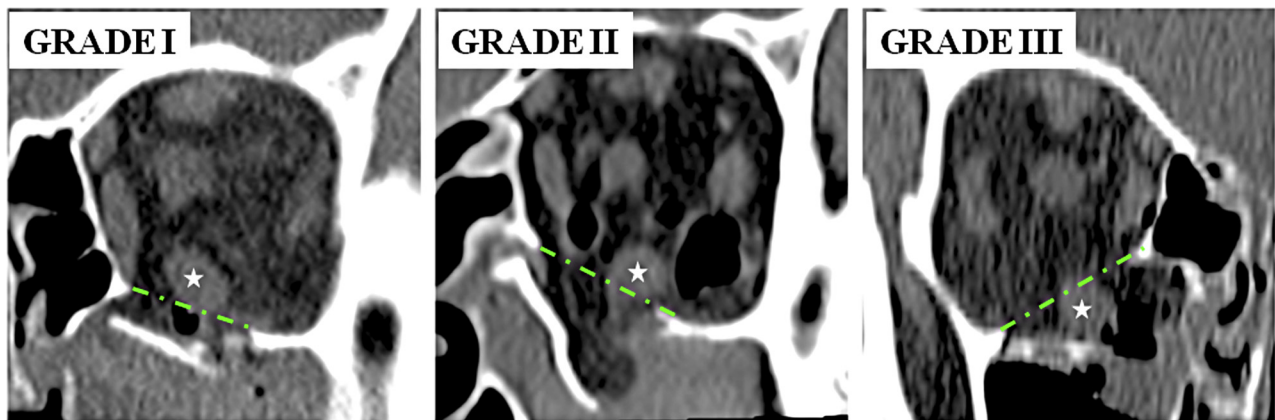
Coronal computed tomography scan images showing degree of downward displacement of inferior rectus muscle (*stars*) relative to level of fracture edge. The *green lines* are virtual lines connecting the medial and lateral edges of the orbital floor fracture.
